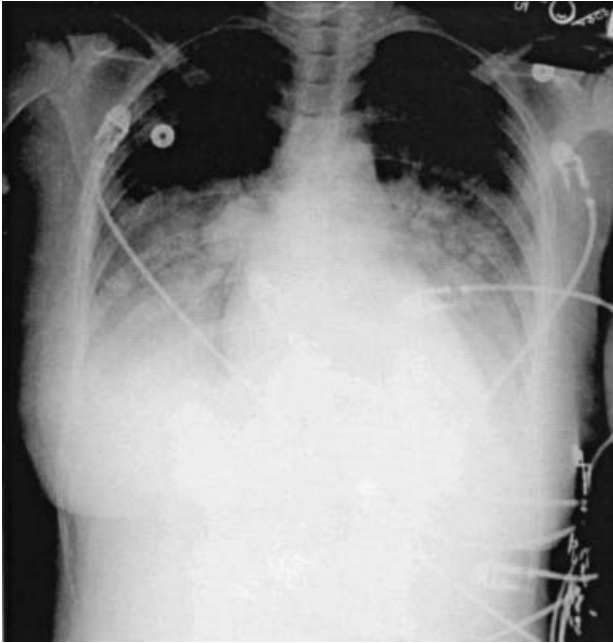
Chest radiograph demonstrating bilateral effusions.
